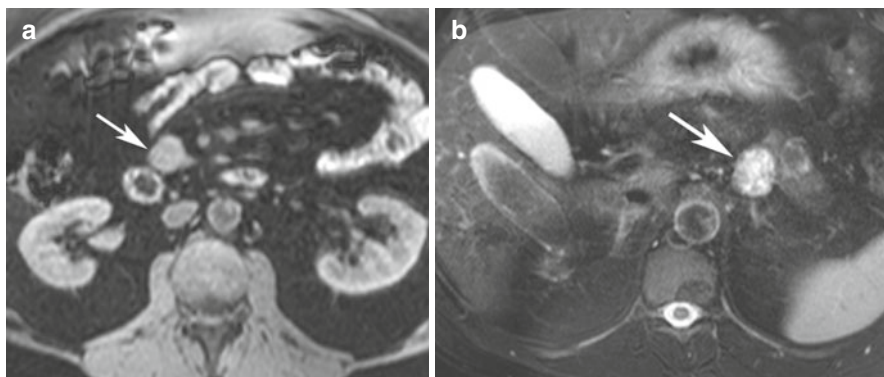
Multiple pancreatic NETs in patient with MEN1. MRI evaluation. (a) T1W fat saturated demonstrates a lesion in the uncinus process; (b) T2W fat-saturated images shows a high-signal-intensity lesion arising from the tail of the pancreas
